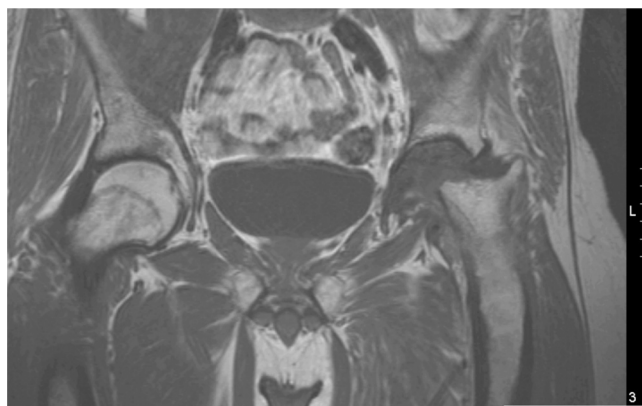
MRI of the pelvis (coronal slice).
